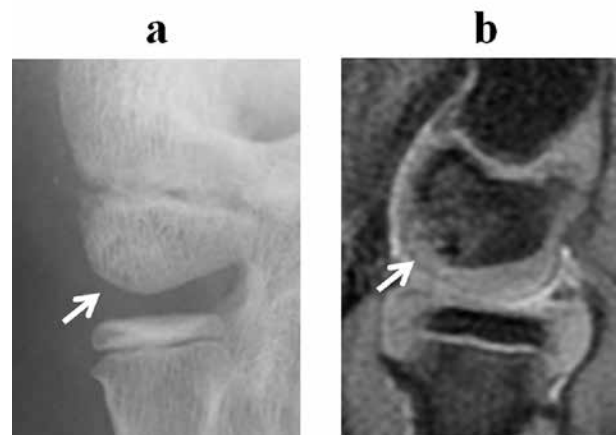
(a) Radiograph demonstrating only subtle changes. (b) Magnetic resonance scan reveals high signal intensity in the subchondral bone of the capitellum on sagittal proton-density fat-saturated images, indicating osteochondritis dissecans of the capitellum.
